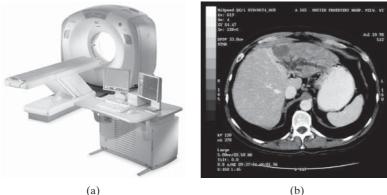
(a) A CT scanner and (b) a CT image of a slice through the liver. Source: Courtesy of GE Healthcare.
